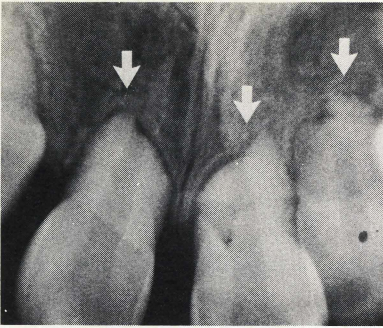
Maxillary anterior periapical view of the patient taken approximately six months after Figure 1. The external root resorption is more clearly seen.
